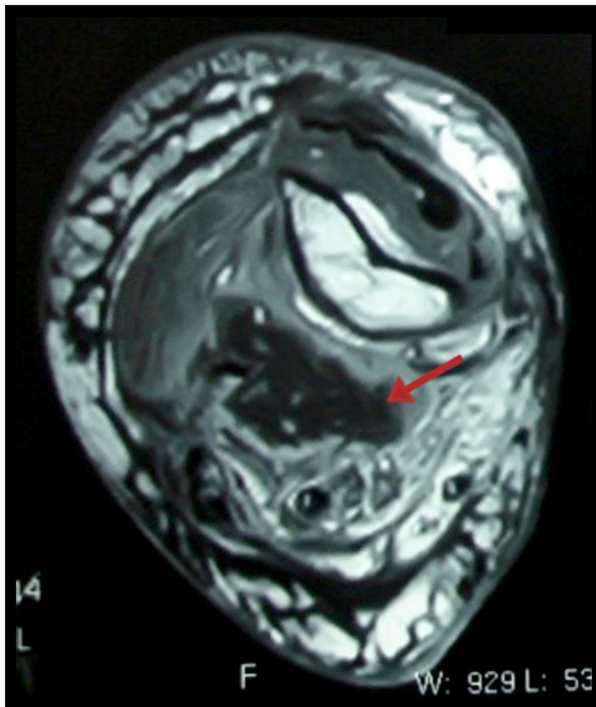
Second MRI (with contrast) conducted 2 weeks after the first MRI is significant for extensive edema centered on biceps, decreased signal intensity of biceps muscle on T1WI, edematous subcutaneous fat layers, and unremarkable bone marrow. Presence of nonhomogenous enhancement is noted after DTPA injection, which is suggestive of necrosis. Necrotic area in biceps muscle has failed to enhance with contrast (arrow).
